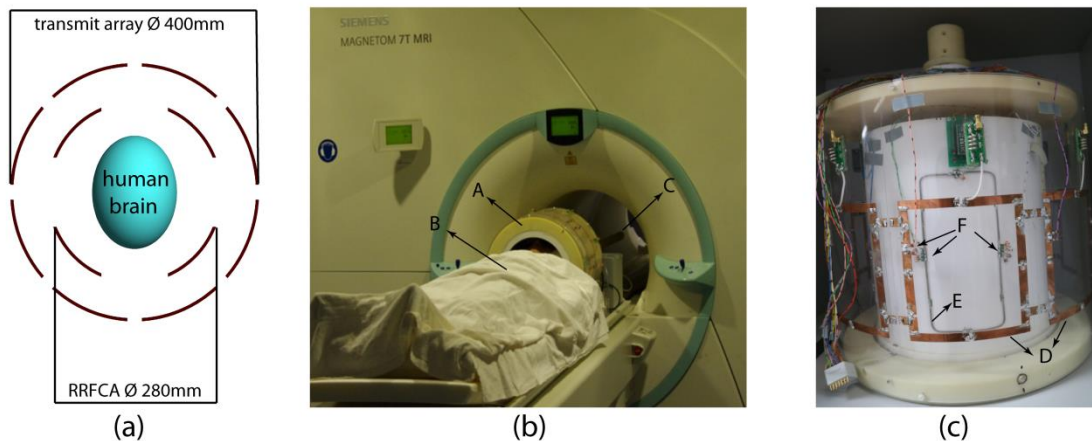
(a) Top view of the RRFCA setup. The outside layer is the stationary 8-element transmit coil array with 400 mm diameter, inner layer is the 4-element RRFCA with 280 mm diameter. (b). RRFCA system loaded with a volunteer. [A] RRFCA system. [B] Volunteer. [C] Extended shaft pointing to rear of MRI. (c). Close-up of the RRFCA system. [D] Transmit coils made of copper patches attached to outside stationary former. [E] Receive coil attached to the internal rotatable former. [F] Detuning circuits on both transmit and receive coils.
